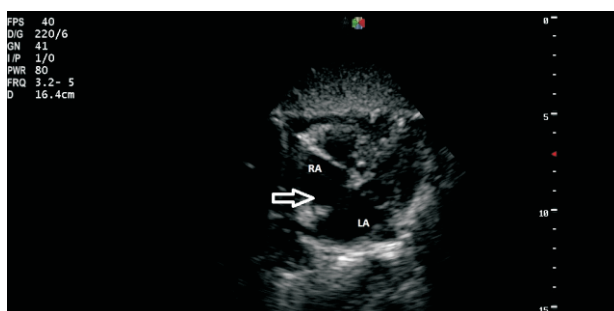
Echocardiogram (subcostal view) showing moderate size ASD (arrow). RA- right atrium, LA-left atrium
